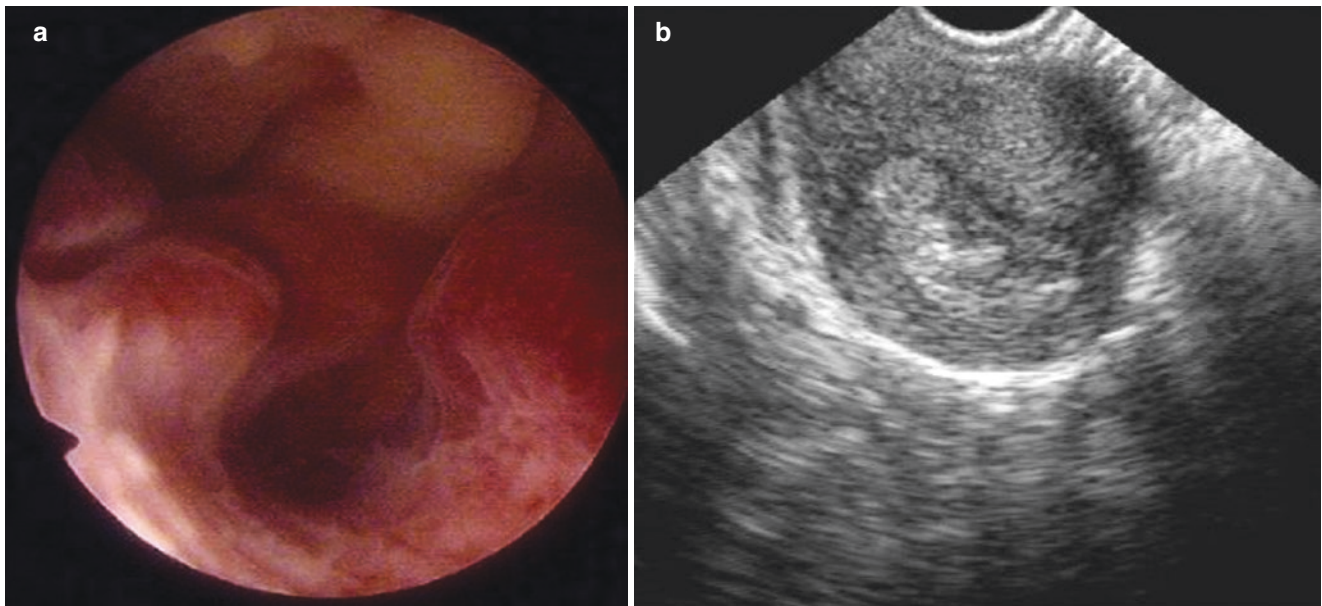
Endometrial polyp. (a) Multiple polyps displayed by hysteroscopy. (b) irregular thickened endometrium shown by ultrasound
